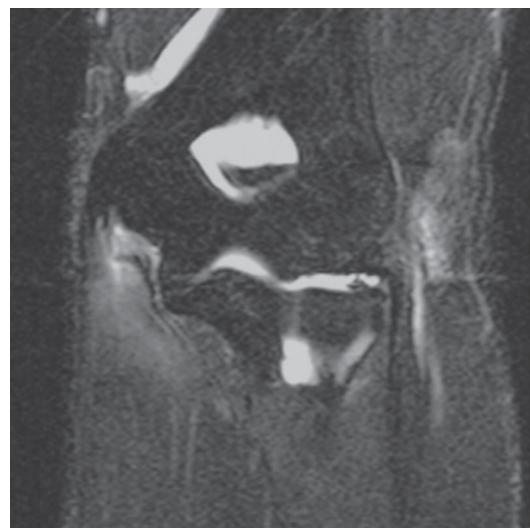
Fluid sensitive coronal MRI demonstrating complete proximal rupture of the UCL
